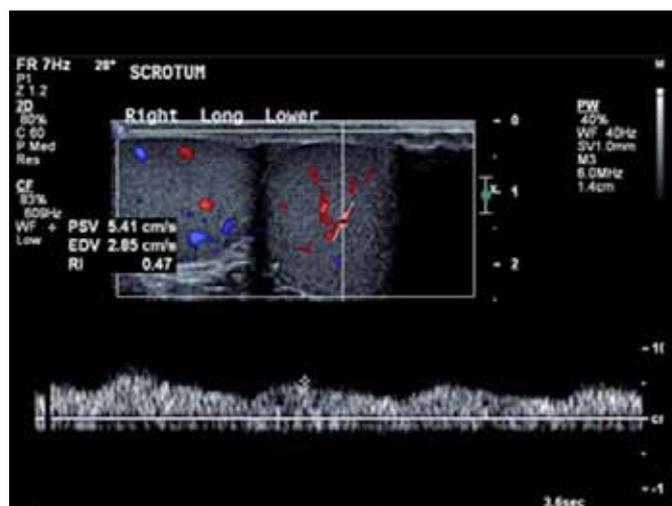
Right lower testis with normal Doppler flow and dimensions (3.5x3.3 cm).
